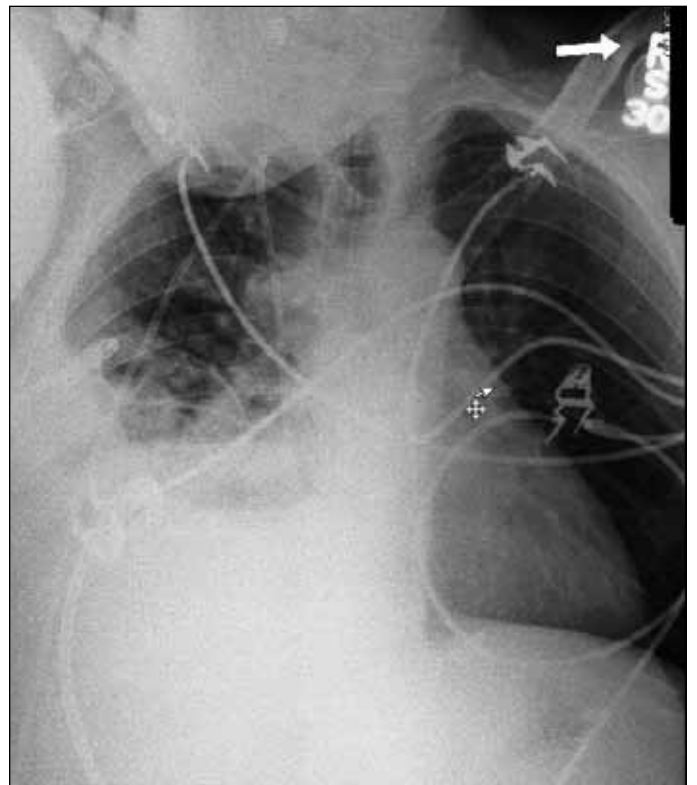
Chest X-ray showing very-elevated right hemi-diaphragm, and moderate to large right pleural effusion.
